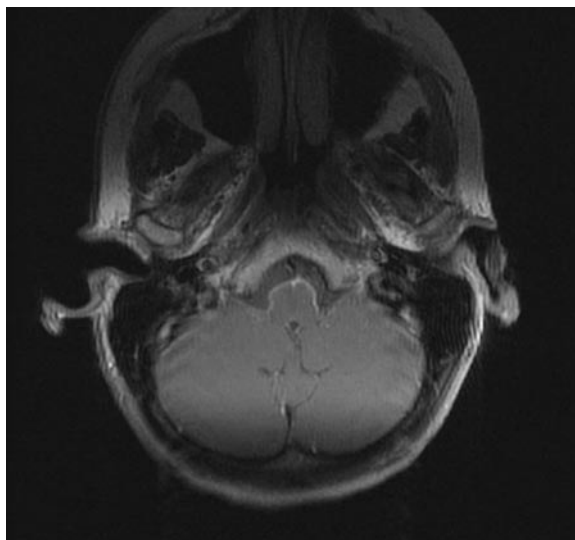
Neuroloues. Axial T1-weighted image after contrast administration. Thickened and contrast-enhancing leptomeninges around the medulla oblongata
